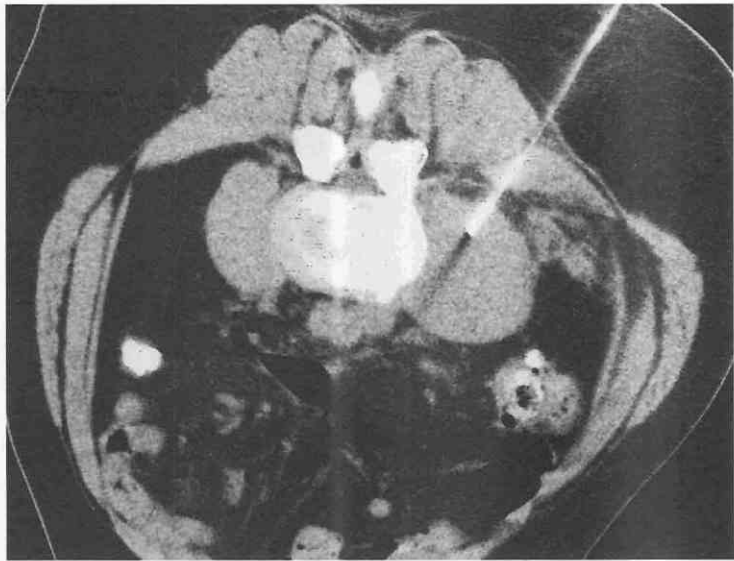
Multiple images from noncontrast CT (A) and CT fluoroscopy (B and C) sequences during a biopsy of a mixed lytic and sclerotic lesion in T12 vertebra. These images demonstrate the successful biopsy of this small lesion (A) (arrows). Note that the needle angle trajectory avoids the left kidney, rib, and pedicle (arrows). The cytologic diagnosis was metastatic adenocarcinoma consistent with a breast origin.
